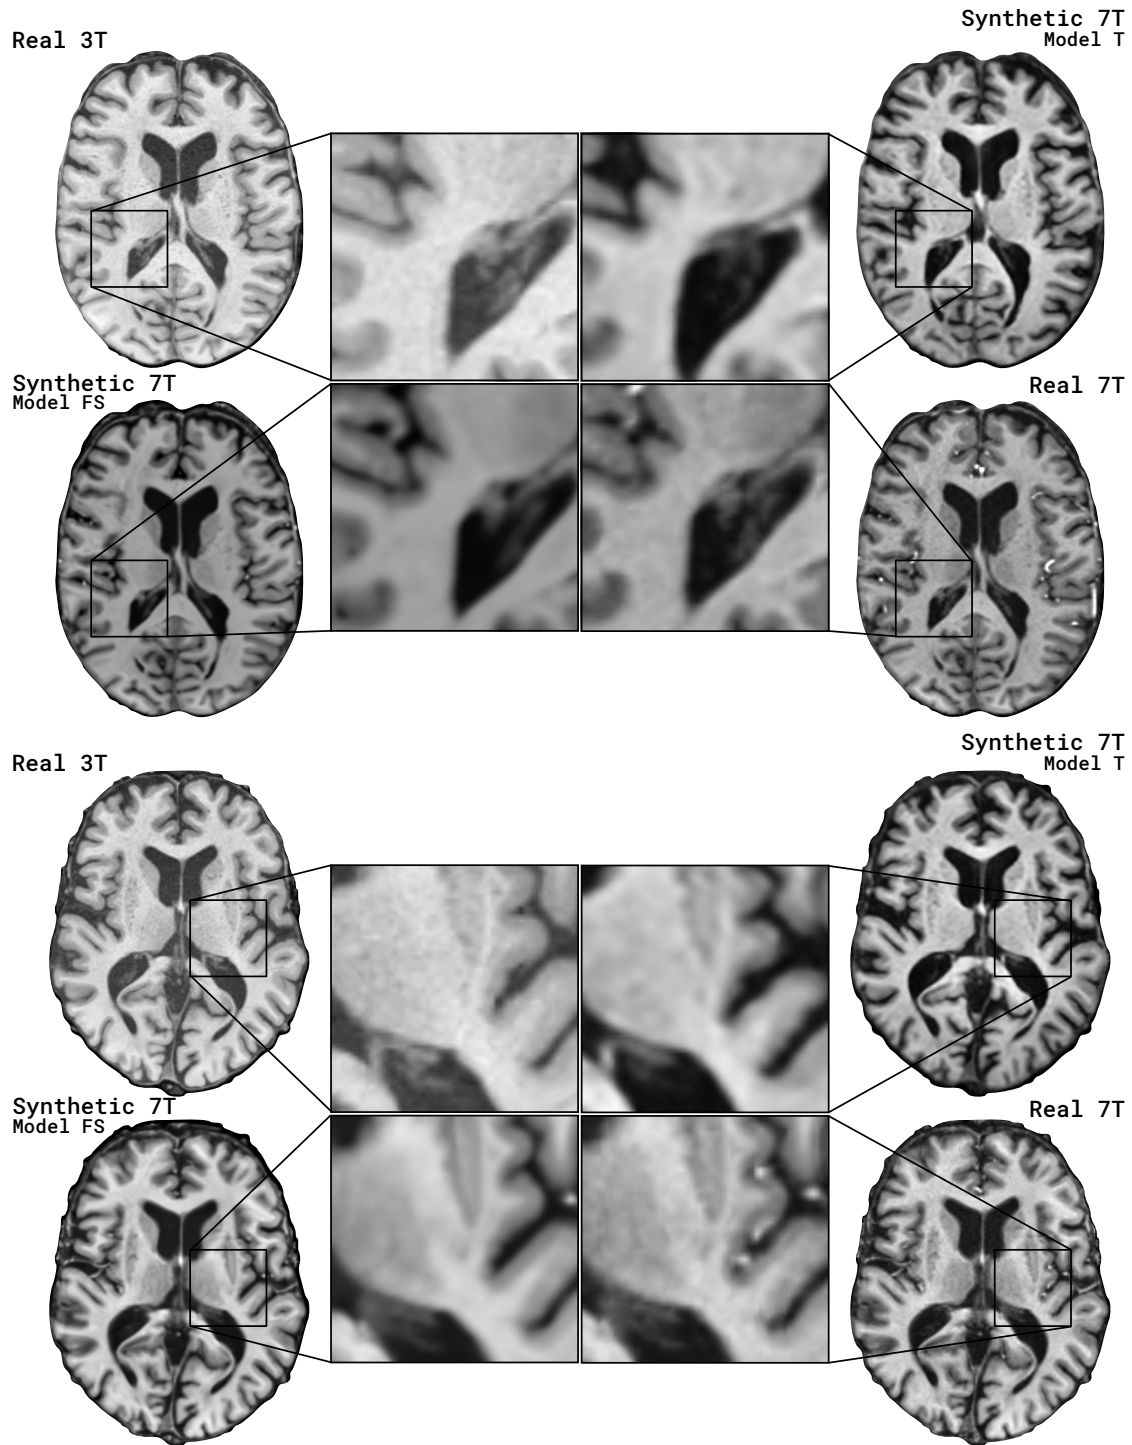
Examples of paired, real 3T and 7T MR images and the corresponding synthetic 7T images generated by the Traditional (T) and Fast-Slow (FS) CycleGAN model.
